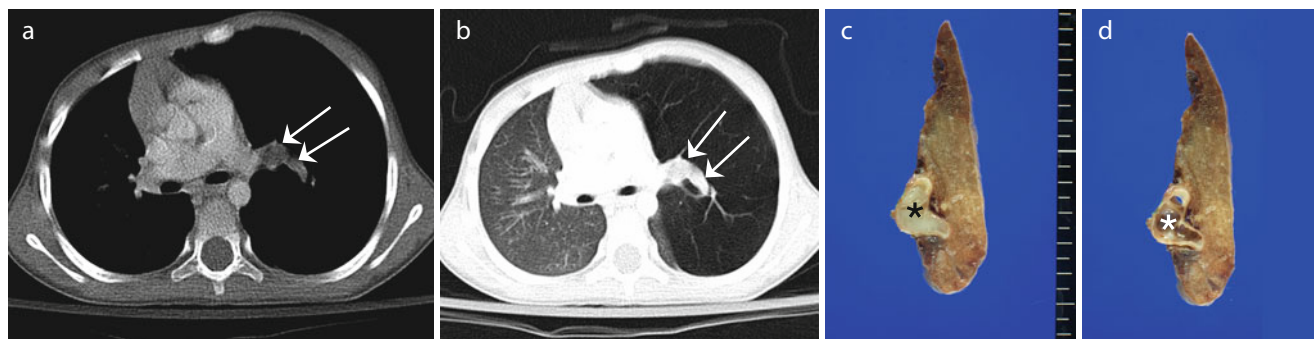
(a–d) Bronchial atresia. Axial CT images with mediastinal (a) and lung (b) window settings show a hypodense mucocoele (arrows) in the central area of the hyperinflated left upper lobe. Photographs
